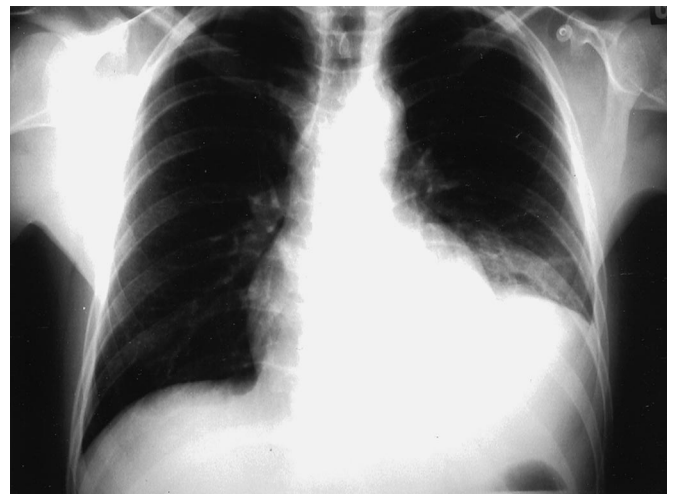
Plain chest x-ray showing a left sided pleural effusion and nonvisualization of the left diaphragm. The gastric air bubble seems to be infradiaphragmatic.
